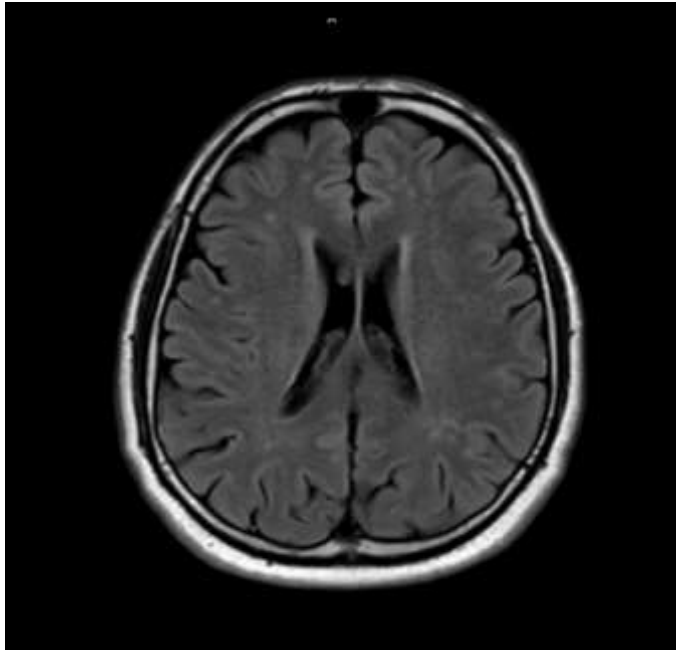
Axial MRI brain-IAC FLAIR-long TR image for patient number 12 shows microvascular disease.
